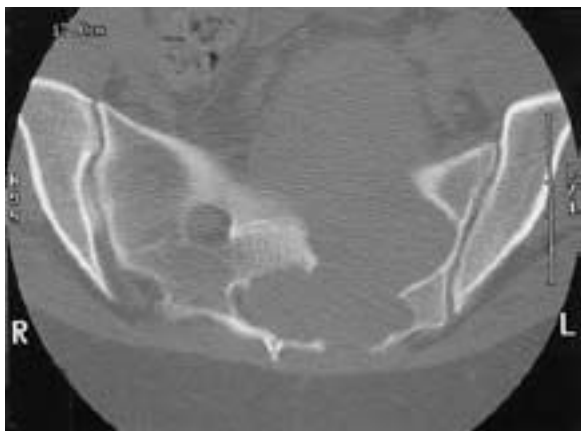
Axial bone window CT scan revealing a large left sacral mass expanding into the presacral space. Note the markedly enlarged left neural foramen compared with the normal one on the right. The sclerotic margins suggest that the mass is slow growing and has been present for some time.
